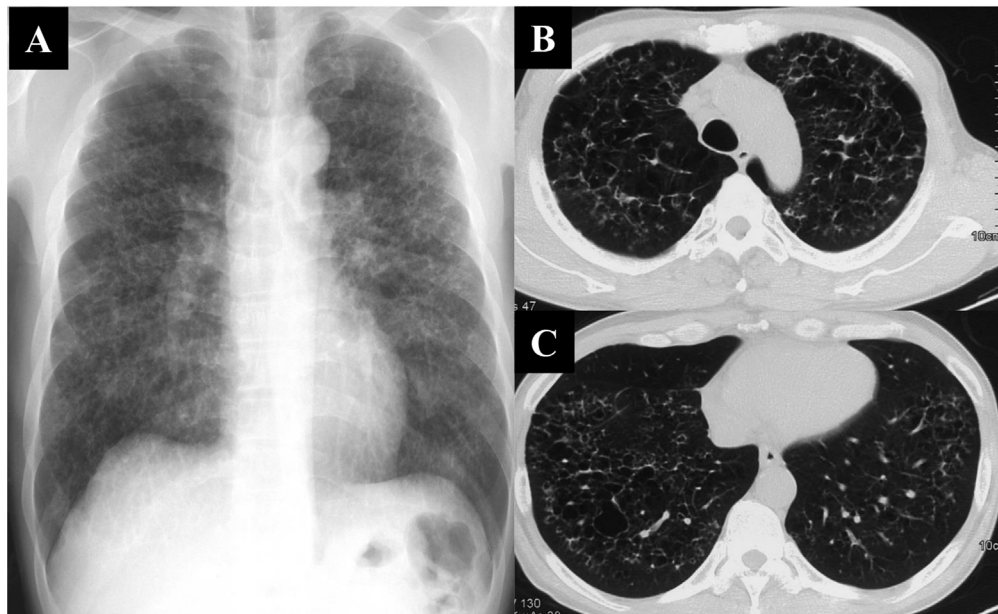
(A) Chest X-ray showing diffuse cysts with reticular shadows in bilateral lung fields. (B, C) Chest CT showing diffuse irregular- and thick-walled cysts with reticulonodular shadows that were predominant in the upper lobes of the lungs.
